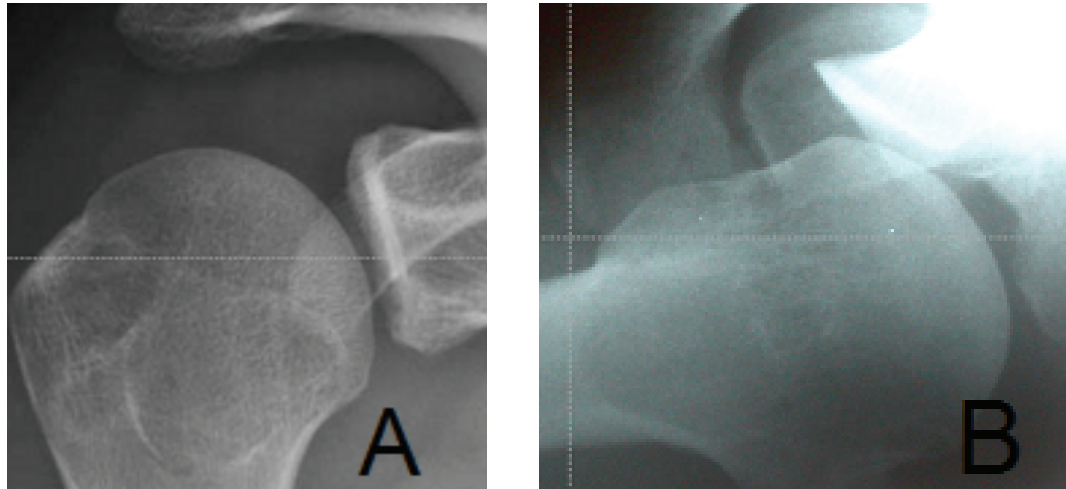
Radiographic evaluation of glenohumeral joint. True AP view showing lost contour of inferior glenoid (A); Axial West-Point view showing anterior glenoid defect (rounded rim) (B).
